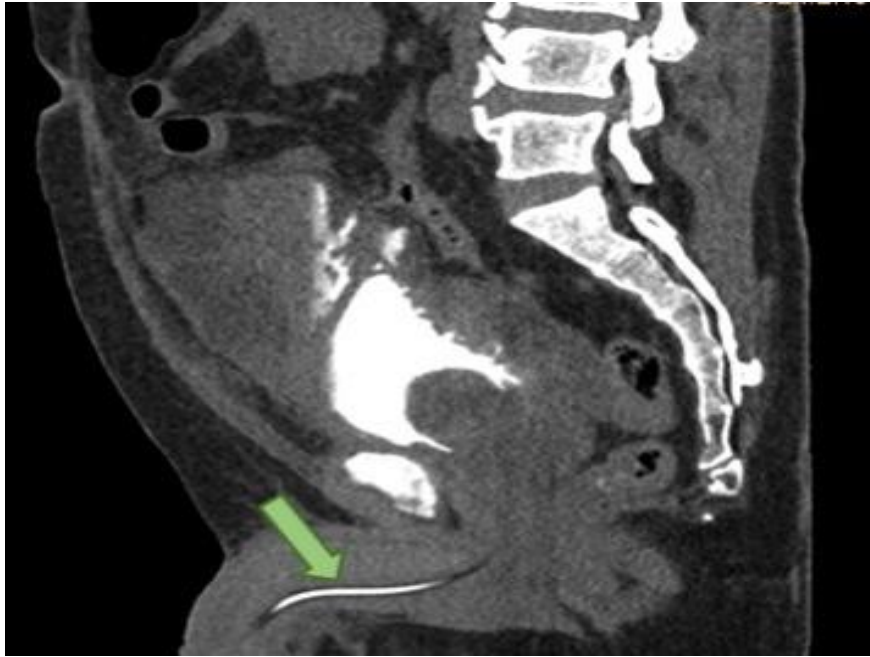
Sagittal slice of an abdominopelvic CT scan after contrast injection, revealing contrast at the level of the urinary catheter.
